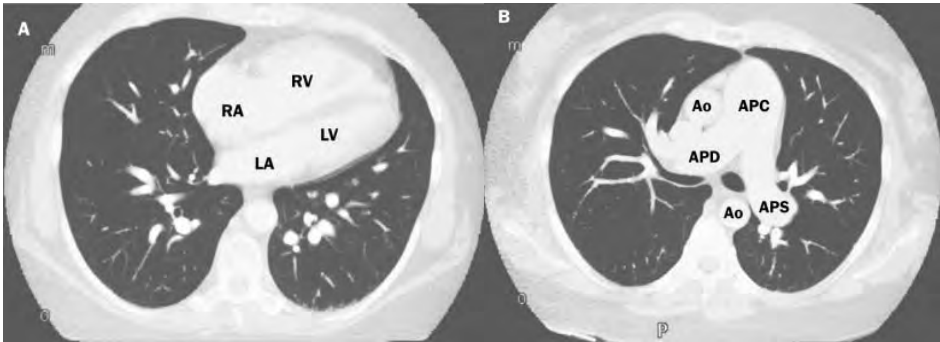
A. CT image which clearly shows the marked dilation of the right atrium and right ventricle, whereas the left atrium and left ventricle are considerably smaller. B. CT image of the aorta and pulmonary arteries. The diameter of the common pulmonary artery is almost twice that of the ascending aorta, and the right and left pulmonary arteries are also dilated. The severe dilatation of the pulmonary arteries indicates that the pulmonary arterial hypertension is not of recent onset, but a chronic condition. RA=right atrium, RV=right ventricle, LA=left atrium, LV=left ventricle, Ao=aorta, APC=common pulmonary artery, APD=right pulmonary artery, APS=left pulmonary artery.
